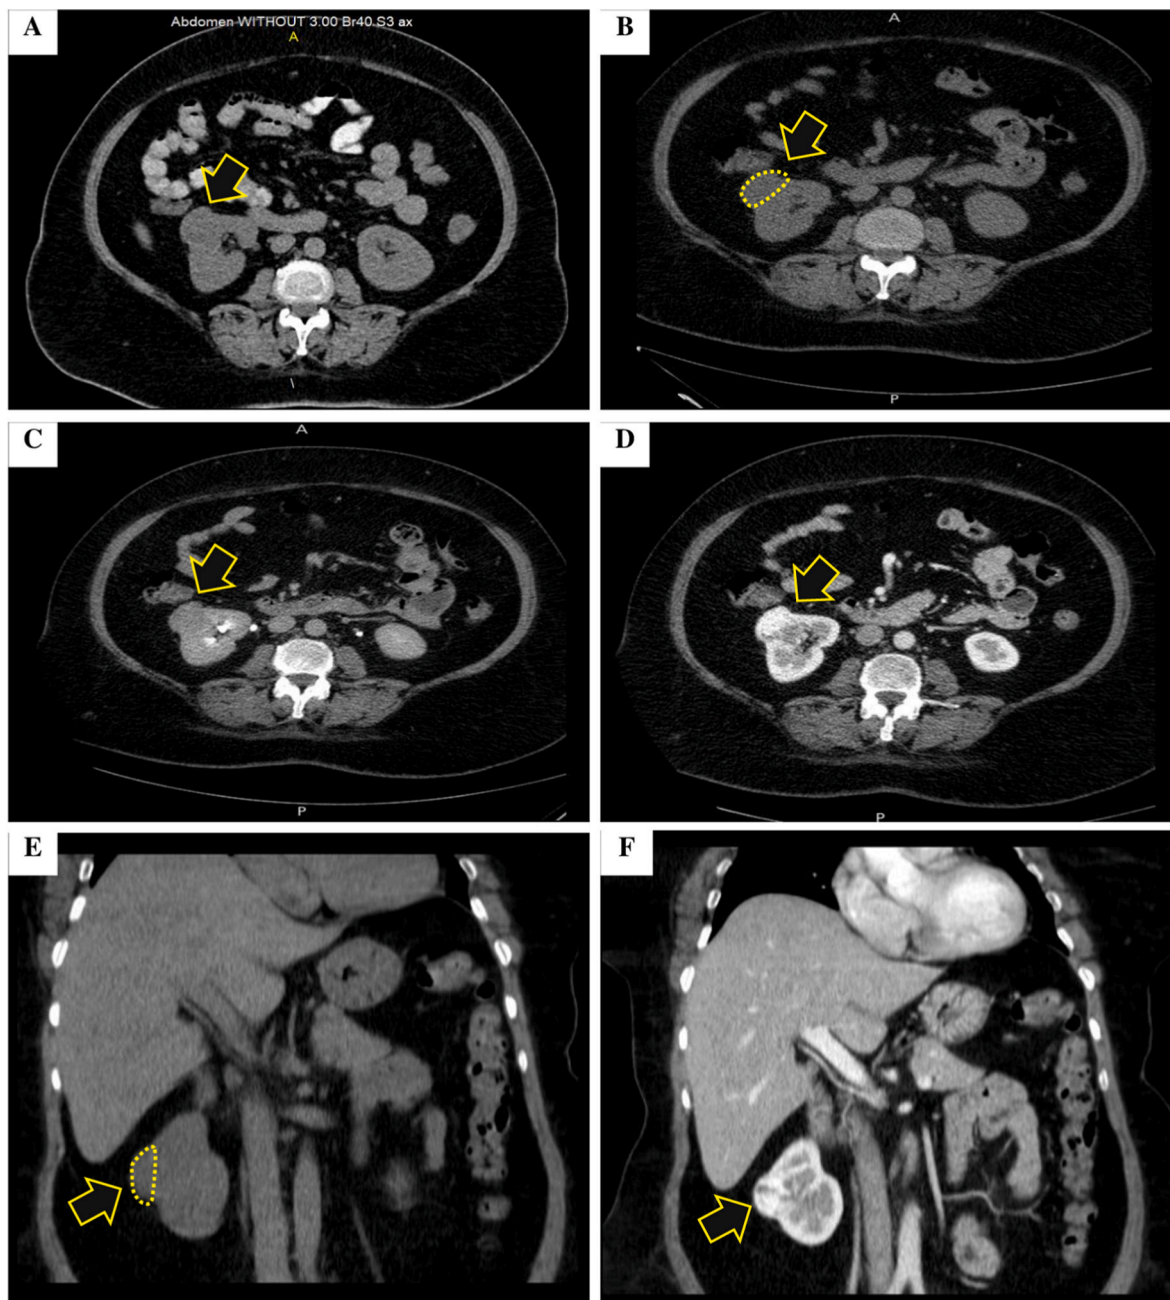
(A, B, C & D) is an axial computed tomography scans with various sequences showing an enhancing soft tissue lesion measuring 3 cm × 3 cm in the right kidney, partially exophytic, extending from the renal pelvis outside, and located in the anterolateral aspect (arrows). (E & F) is a coronal computed tomography scans with and without contrast (A & B, respectively) demonstrating the right renal mass (arrows).
